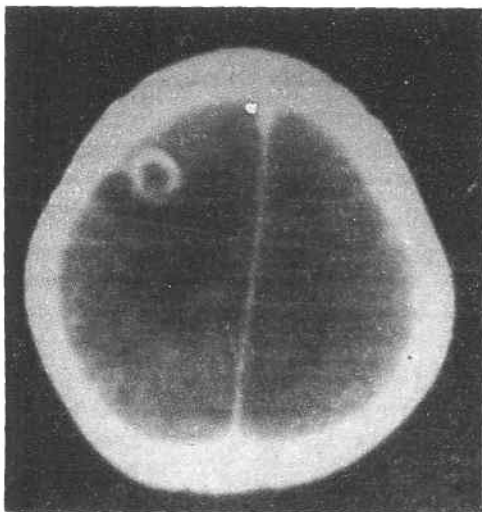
Contrast enhanced cranial CT scan showing 'single small enhancing ring lesion'.
